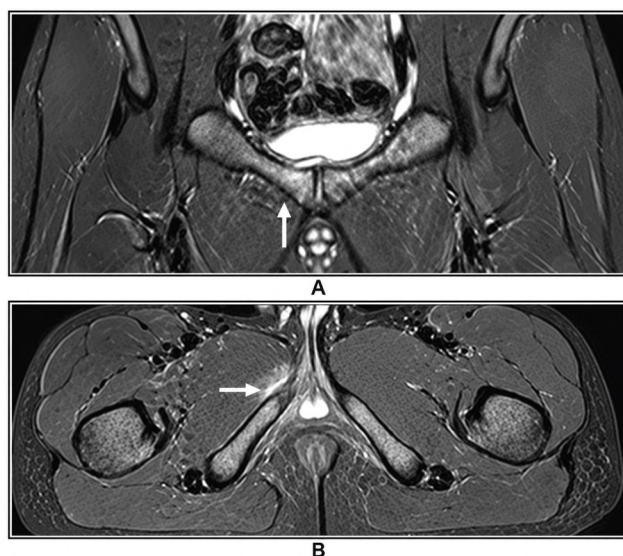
Coronal (A) and axial (B) magnetic resonance images demonstrate bone marrow oedema in the pubic bone (white arrow) and surrounding soft tissues (black arrow) on the right side
